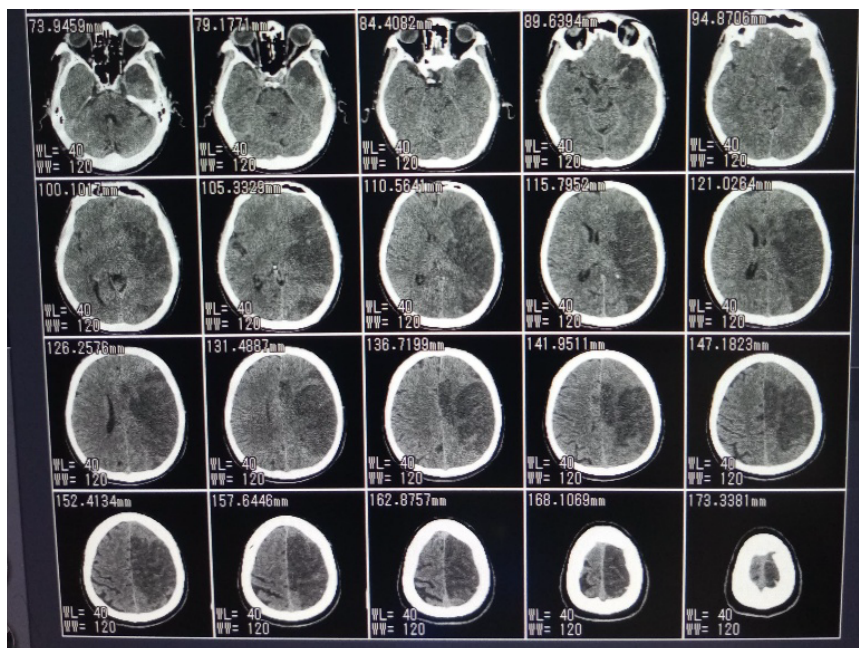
non-contrast head CT-scan of MR. S
